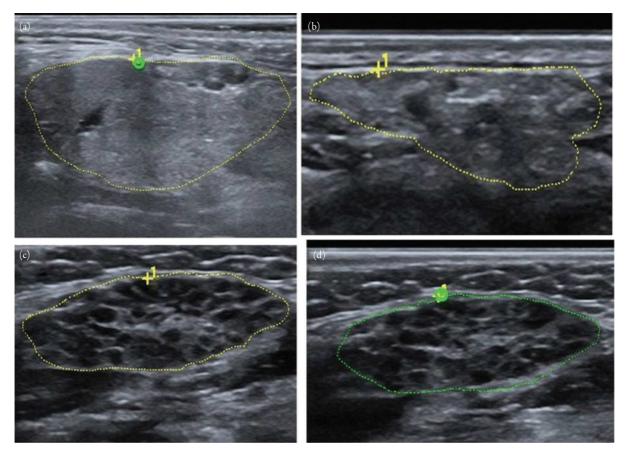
Ultrasound image showing parenchymal inhomogeneity in the submandibular salivary glands. (a) Normal submandibular gland. (b) Submandibular gland with evident inhomogeneity. (c) and (d) Submandibular glands with gross inhomogeneity. Adapted from Figure 1 of Baldini C, Luciano N, Tarantini G, et al. Salivary gland ultrasonography: a highly specific tool for the early diagnosis of primary Sjögren's syndrome. Arthritis Res Ther. 2015;17(1):146. doi:10.1186/s13075-015-0657-7.
